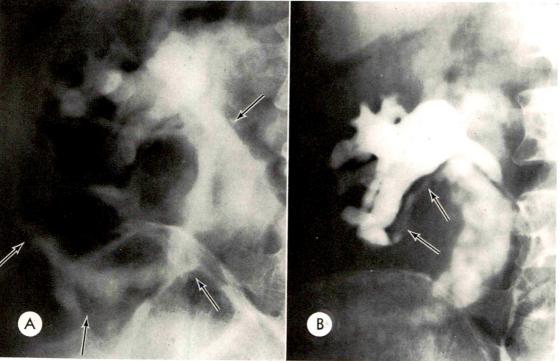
(A) Arrows point to contrast-laden urine dissecting through the hilus of the right kidney into peripelvic and perirenal fat on this 1 hour roentgenogram during an excretory urography. The pyelosinous backflow was caused by lower ureteral obstruction from a stone. (B) A later retrograde pyelogram demonstrates that the extravasation continues and the actual tract (arrows) communicating with the fornix of the lower calyx is seen more clearly than on the original excretory urogram. The patient subsequently passed a small stone spontaneously and follow-up urograms were normal. (Reproduced by permission from the Southern Medical Journal.)
